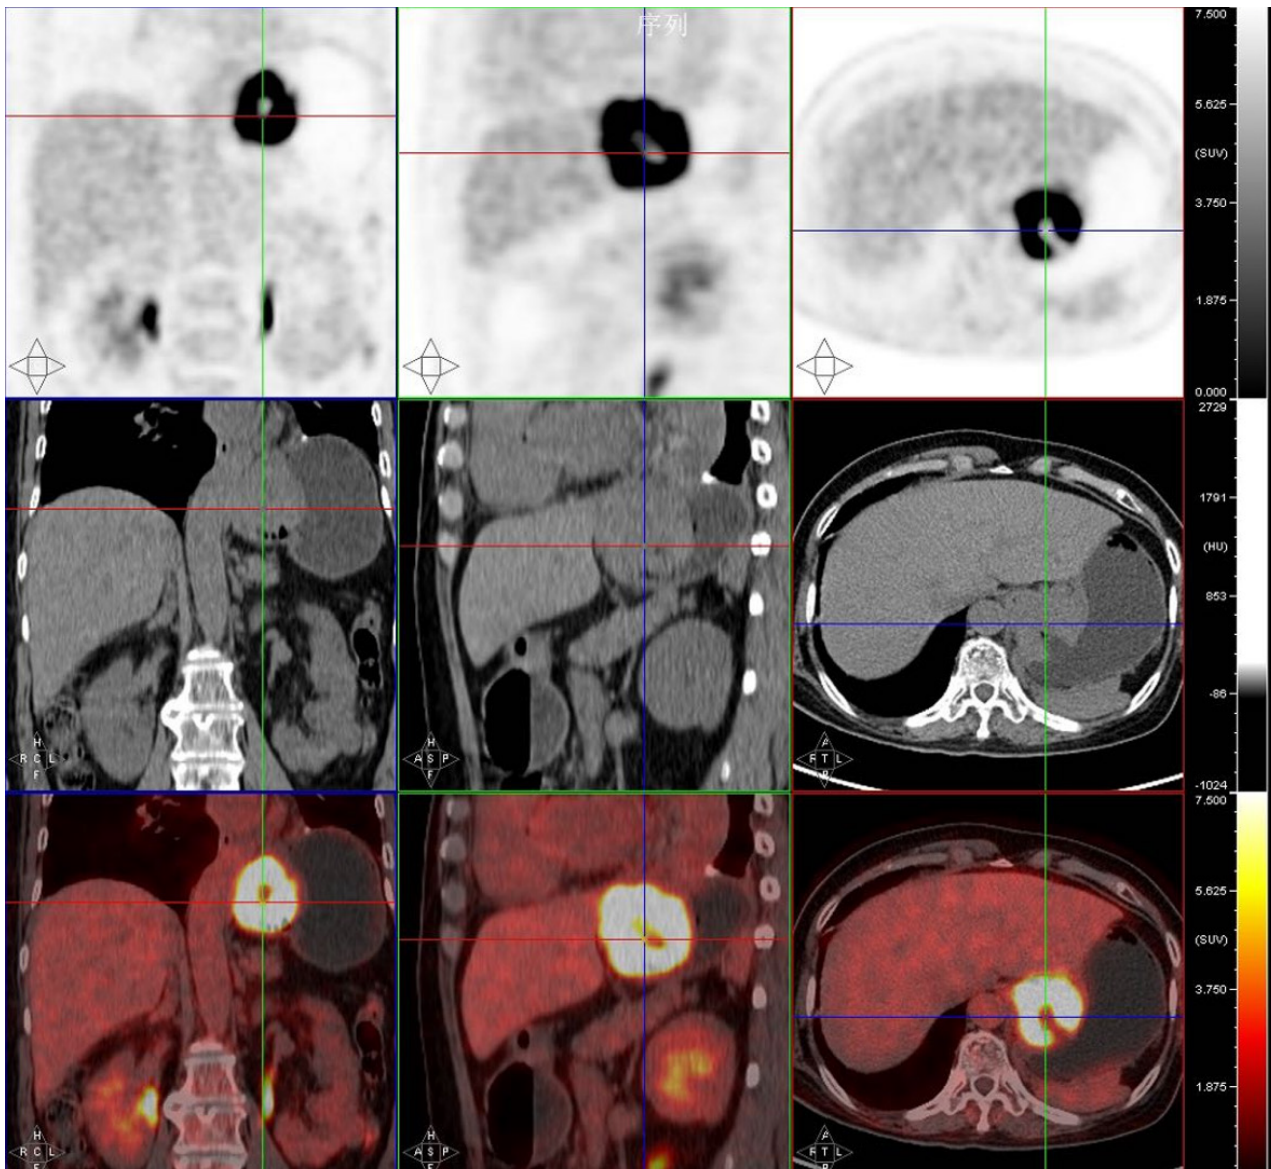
Positron emission tomography/computed tomography showing high accumulation of ^{18}F -fluorodeoxyglucose in the gastric cardia region. A maximum standardized uptake value of 20.03.
